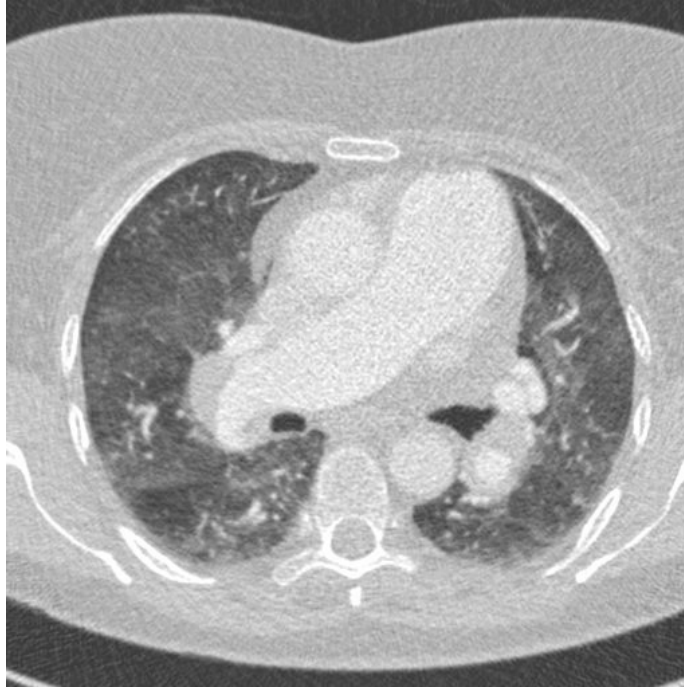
Representative CT scan of a patient from our PH pilot study, suspect of PH caused by left heart disease.
